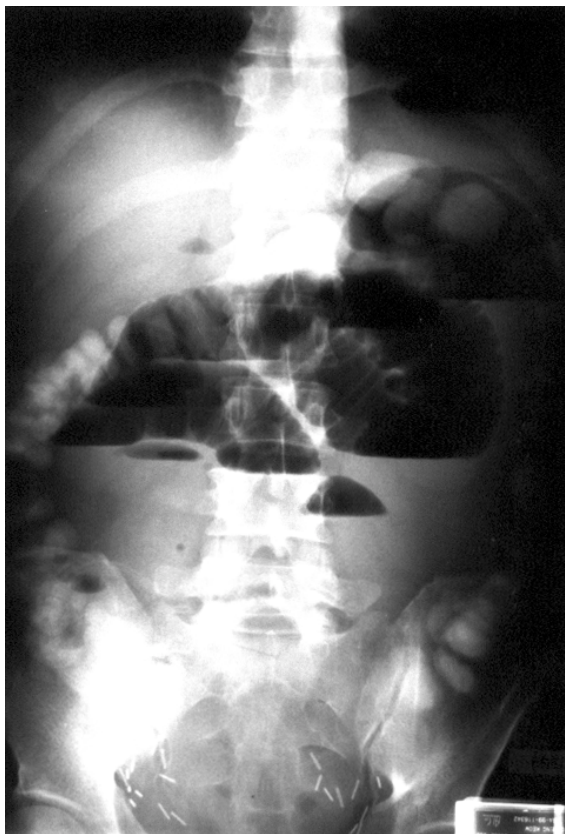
Erect abdominal radiograph shows multiple loops of dilated small bowel, with several air-fluid levels
